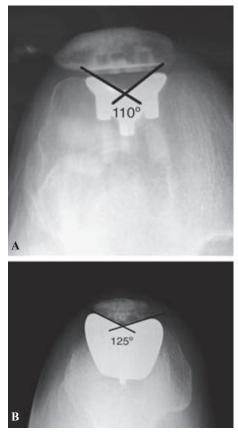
[A] The skyline radiograph shows the trochlear sulcus angle of the Lubinus prosthesis is approximately 110°. [B] The skyline radiograph shows the broader trochlear sulcus angle of the Avon prosthesis is approximately 125°.
